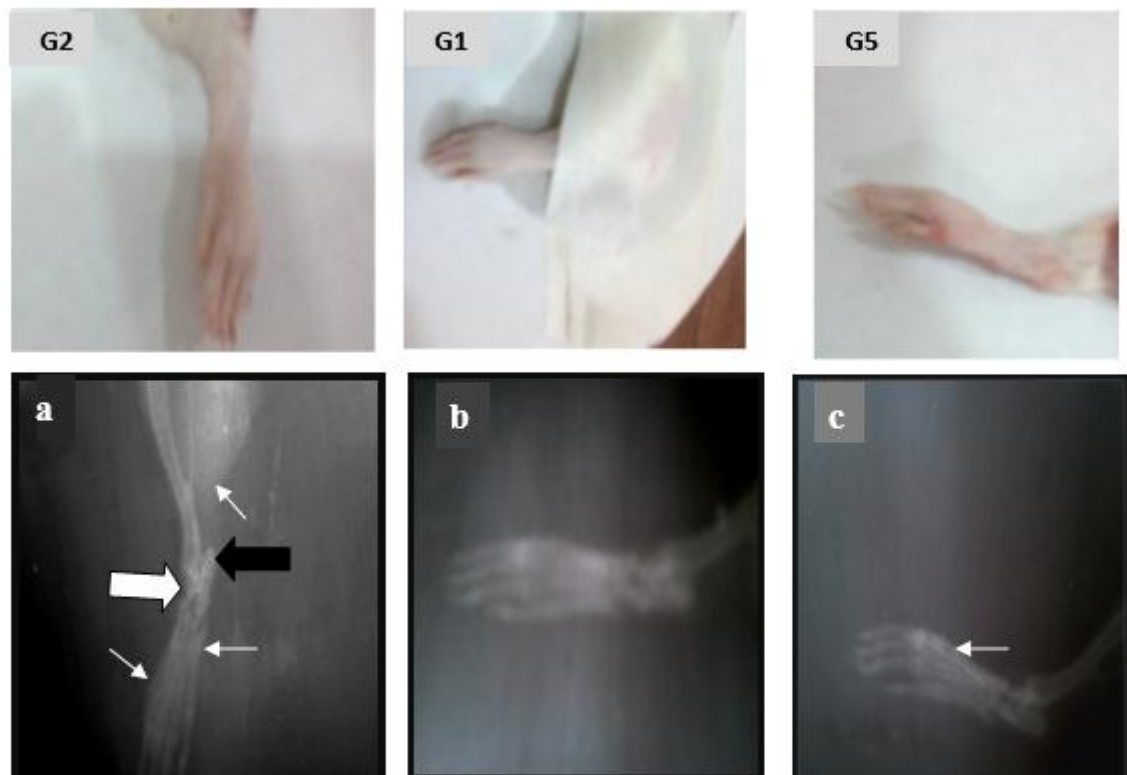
Radiographic images from formaldehyde solution (G2) negative control (a) appear tissue swelling (small arrows), bone erosion (black arrows) and osteophyte formation (thick white arrow). (G1) normal control (b) showing a normal ankle joint. (G5) given 1 ml / day / oral of camel milk (c) appear a mild tissue swelling (small arrow).
